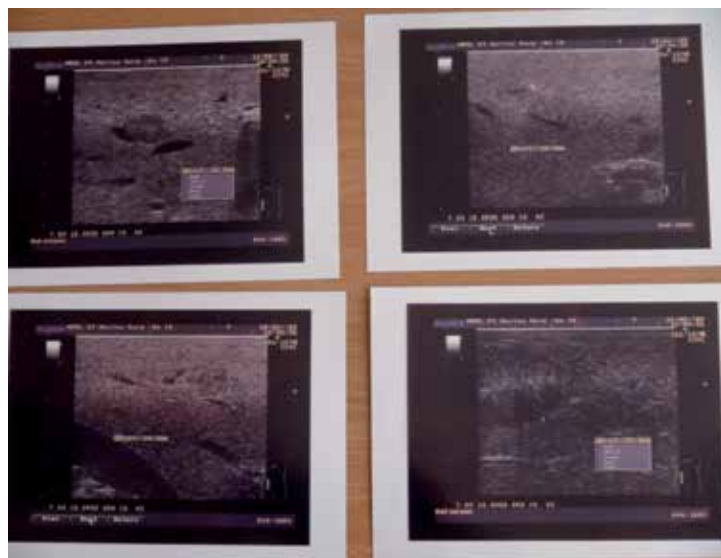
Intraoperative ultrasound of the liver
